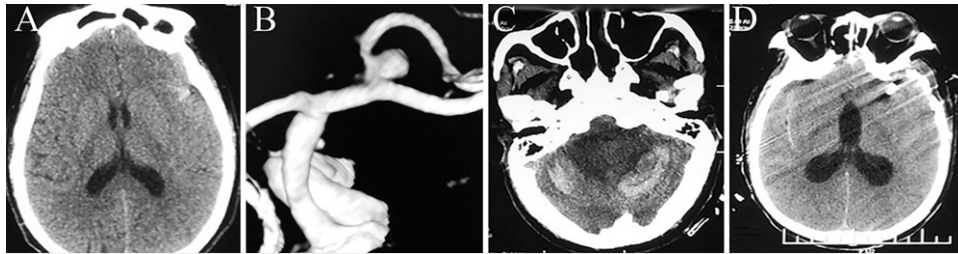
A: Preoperative CT revealed a small amount of subarachnoid hemorrhage in the left lateral fissure. B: Preoperative DSA revealed an aneurysm of the left middle cerebral artery. C: At 8 hours postoperatively, CT showed bilateral cerebellar hemorrhage. D: At 18 hours postoperatively, a second CT scan revealed hydrocephalus.
